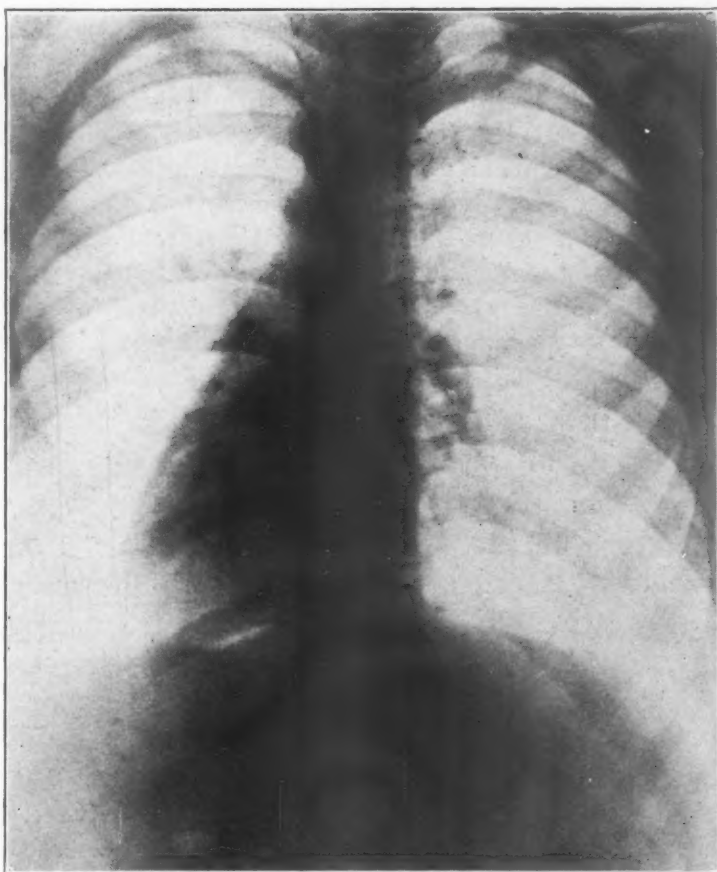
X-ray of the heart at 2 meters.
